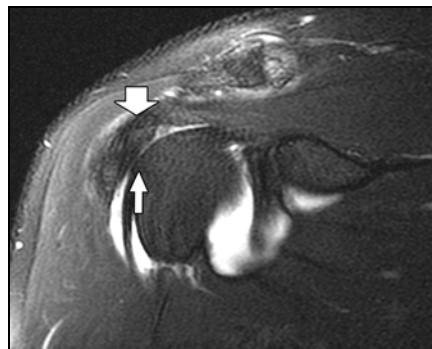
46-year-old man with full-thickness rotator cuff tear. Coronal oblique fat-suppressed fast spin-echo T2-weighted (TR/TE, 4,000/66) MR arthrography image shows full-thickness tear of rotator cuff from insertion on greater tuberosity (arrow).
